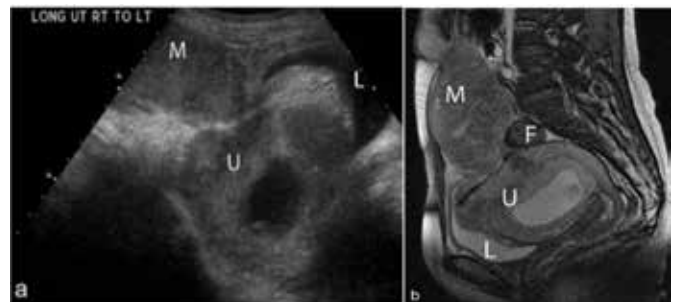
(a) 36-year-old pregnant woman with urachal carcinoma. Longitudinal ultrasound of the pelvis shows a large mass superior to the bladder and anterior to the gravid uterus. (b) Sagittal MRI of the pelvis shows the heterogeneous mass superior to the bladder and extending to the umbilicus.⁷
